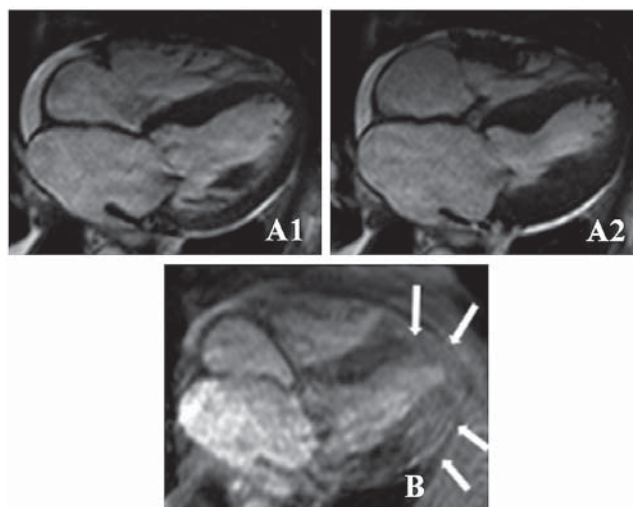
Magnetic resonance imaging (MRI), T2-map sequences; panel A, 4-chamber end-diastolic (panel A1) and end-systolic images (panel A2); (panel B) apical edema (arrows).
